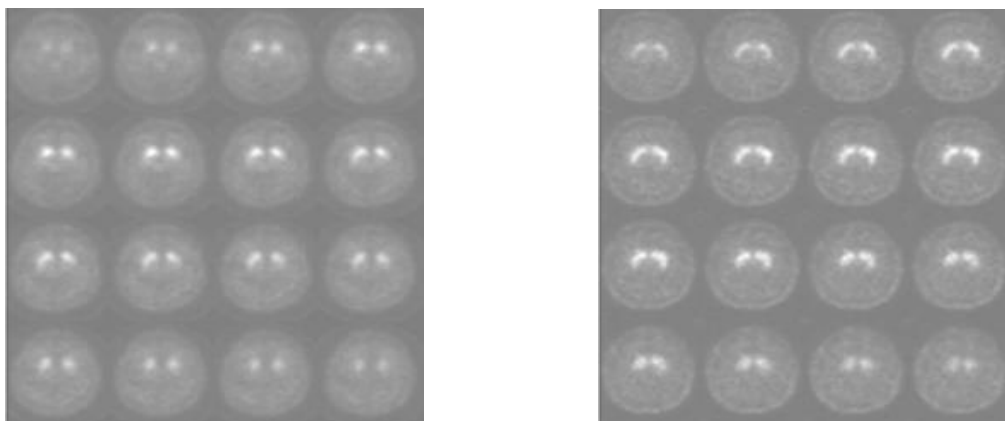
Two-dimensional volume-based image slices chosen from the SPECT (a) early PD (b) HC
